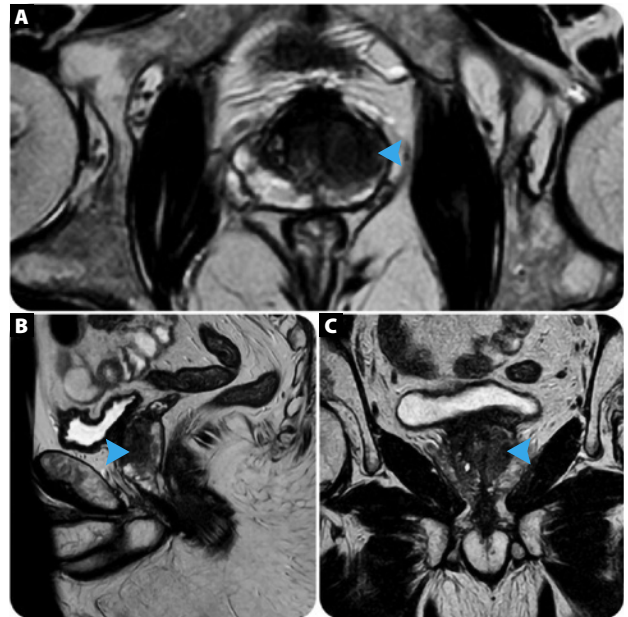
T2-weighted axial (A), sagittal (B), and coronal (C) MR images of the prostate with arrowheads indicating the lesion. Images courtesy of the author.
